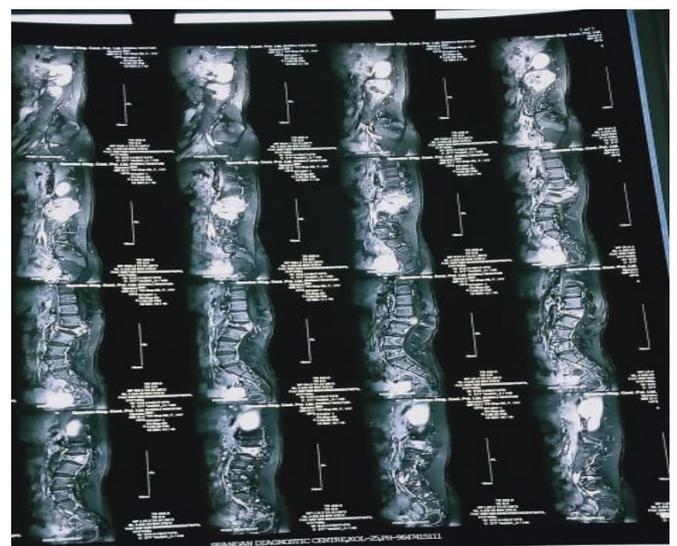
Initial MRI spine showing caries spine with destruction of L2 vertebra.
